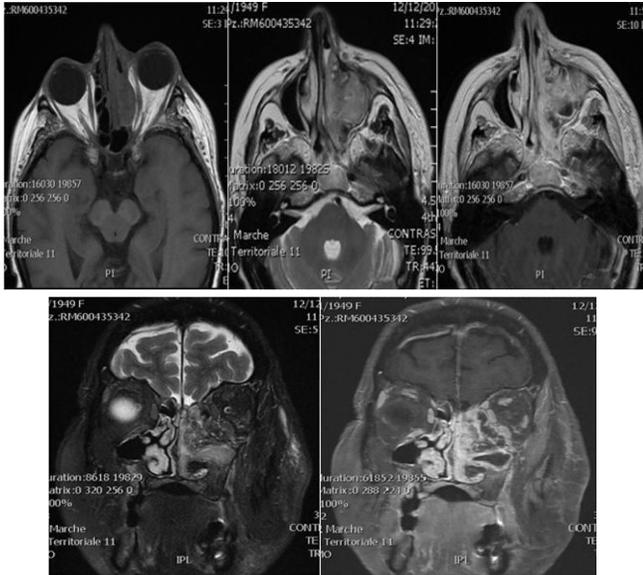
MRI: ethmoidal mass that reaches the medial orbital wall and the medial orbital floor, impinging the medial and inferior rectum muscles, with mild exophthalmos.
